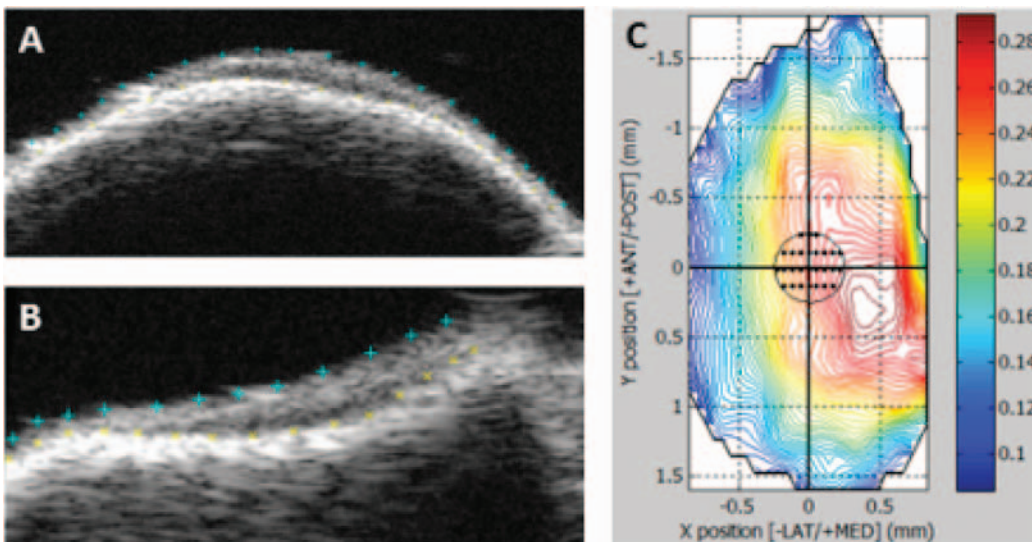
Medial tibial plateau articular cartilage segmentation to determine cartilage thickness. (A) Sagittal and (B) Coronal ultrasound images with markers defining the cartilage with center region of interest defined to average the segmentation points.
